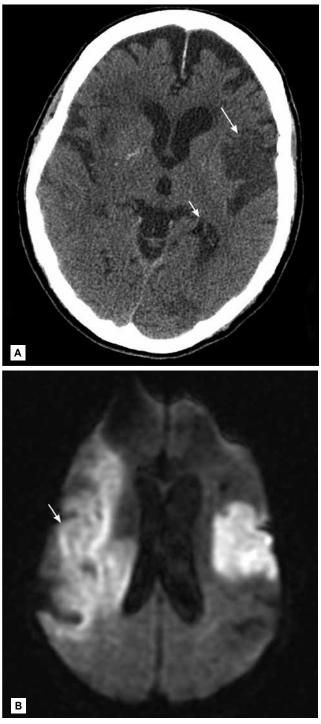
(A) Noncontrast computed tomography showing two hypodense regions indicating old infarctions in the distribution of the left-middle cerebral (*long arrow*) and posterior cerebral arteries (*short arrow*). (B) Diffusion-weighted magnetic resonance imaging obtained shortly after the computed tomography reveals a new extensive infarction (*arrow*) in the right-middle cerebral artery distribution not evident on the computed tomography.
